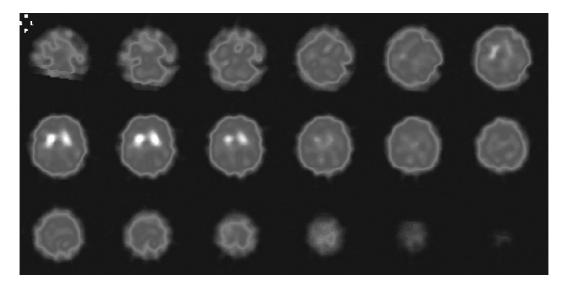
First [1231]IBZM-SPECT investigation of patient no. 7 treated with 600 mg quetiapine. Striatum/occipital ratio: 1.81.
